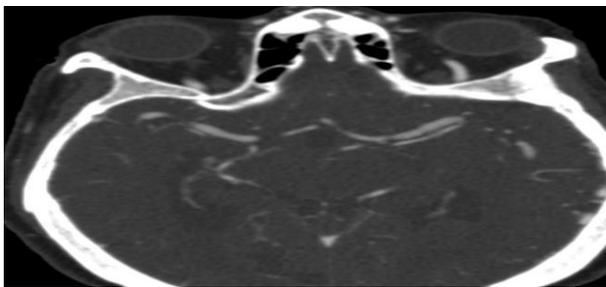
Axial contrast CT angiography MIP image showing bifurcation of left MCA.
